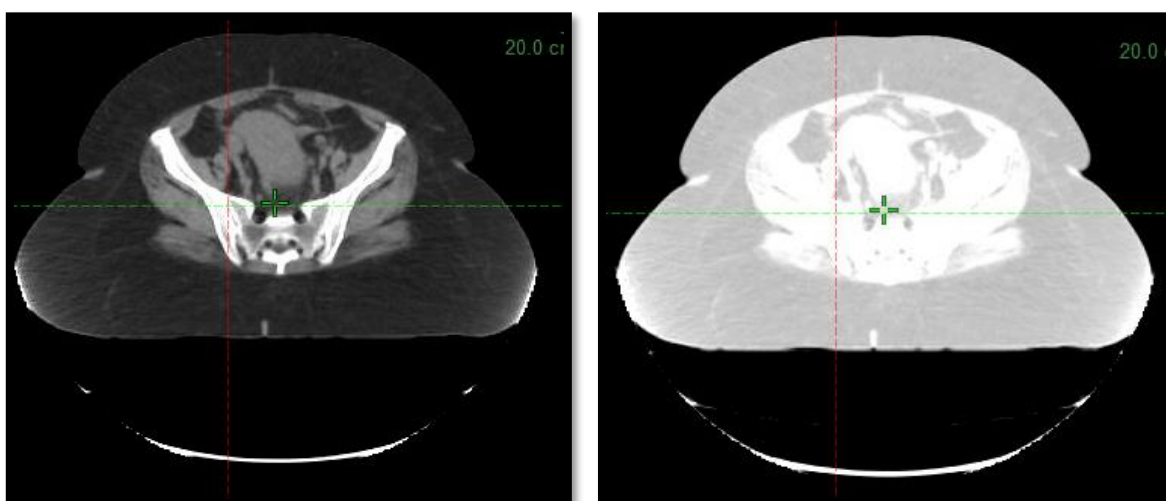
a) Planning CT with a Pelvis window applied (-160 to 240HU) and b) The same planning CT with an adapted lung window applied (-473 to 0HU).
